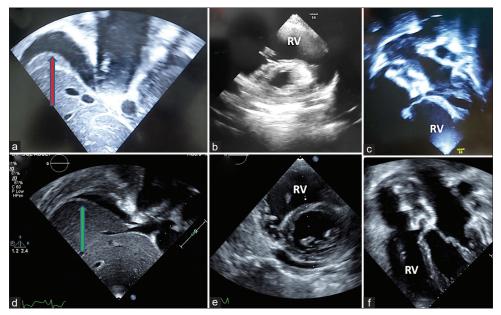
Echocardiogram in (a) subcostal view showing right pleural effusion (red arrow). On the third postprocedure day after the deterioration (b) parasternal short axis view and (c) and apical four-chamber view showing dilated right ventricle. Predischarge echocardiogram showing (d) reduced right pleural effusion (green arrow). Predischarge echocardiogram in parasternal short axis view (e) and (f) apical four-chamber view showing reduction of the RV dilatation and stable device position. RV: Right ventricle
